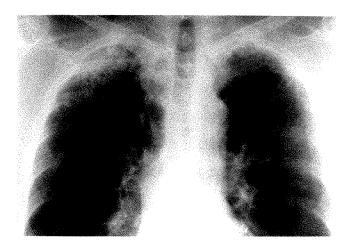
Posteroanterior chest radiograph showing bilateral apical infiltrates.
